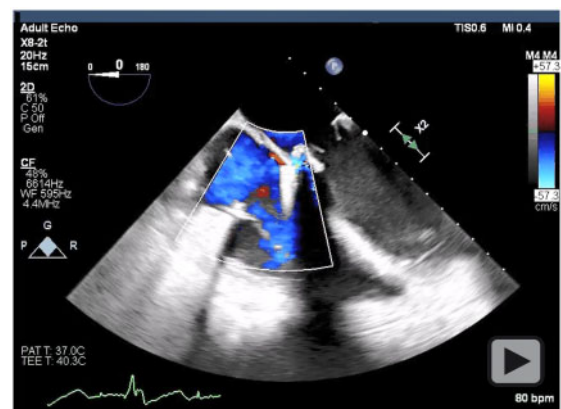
(A, B) Diagnostic transoesophageal echocardiogram demonstrating a centrally directed tricuspid regurgitant jet and a separate, laterally directed jet through an iatrogenic left ventricle-to-right atrial shunt with concomitant tricuspid annular dehiscence and moderate paravalvular leak in the A1 region of the prosthetic mitral valve.
